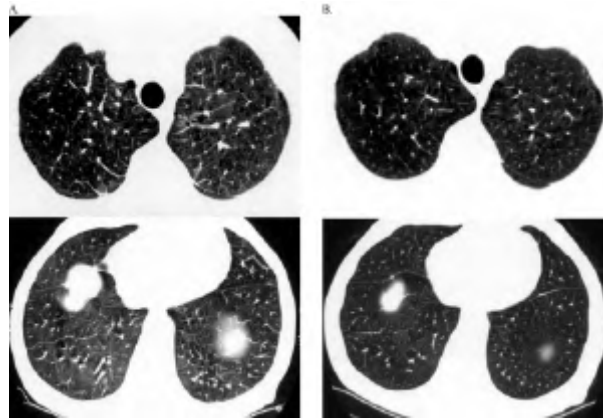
Radiological Manifestations of Pulmonary Leukostasis resolve after Imatinib Therapy. Increased diffuse bilateral reticulation or linearity resembling interstitial edema or lymphangitic carcinomatosis on computed tomography of the chest (A). Findings resolve after initiation of treatment with imatinib (B).
